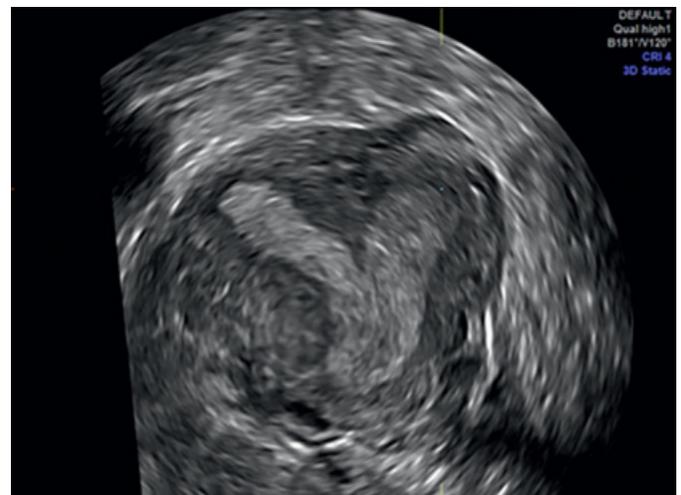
Three-dimensional ultrasound image of uterine septum.
